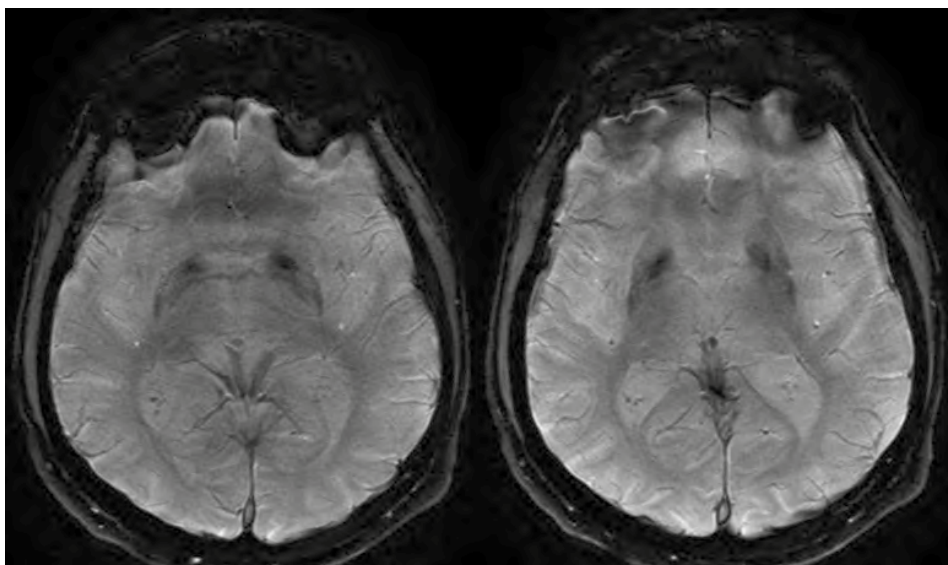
Magnetic Resonance Imaging showing brain iron deposition
